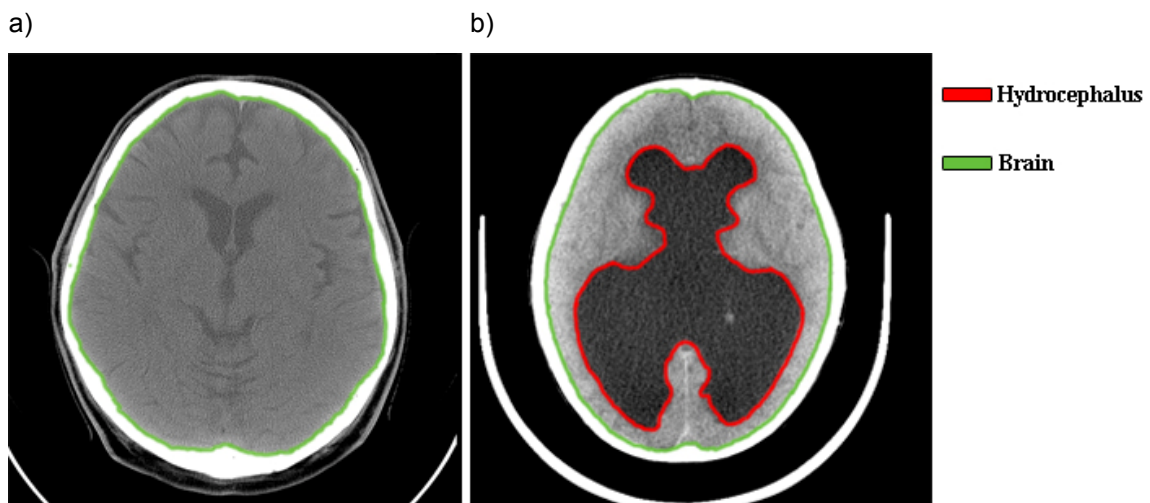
Exemplary CT cross sections of brain:
